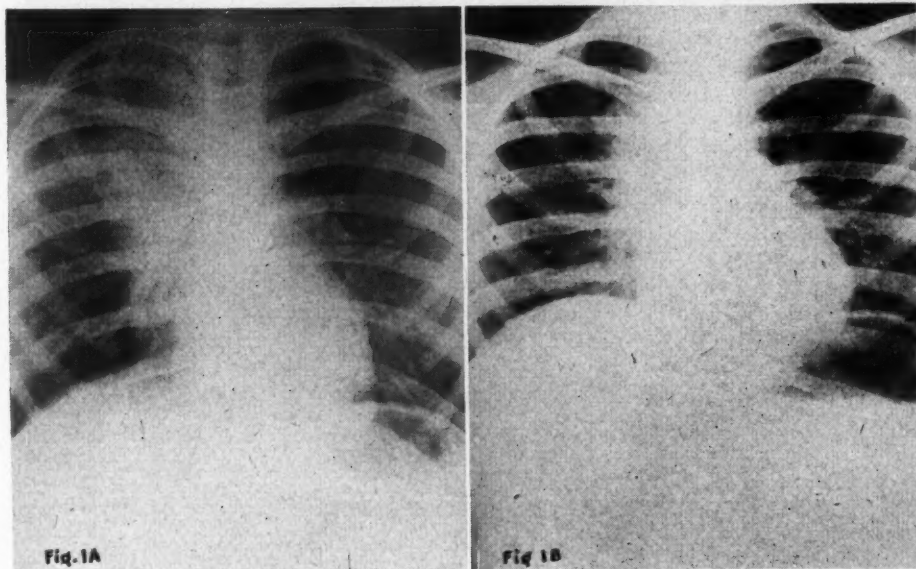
Case 1: B.S. Roentgenogram taken January 26, 1942, showing marked increase in hilar shadows, more marked on the right. There is a diffuse irregular density spreading up from the right hilus.
